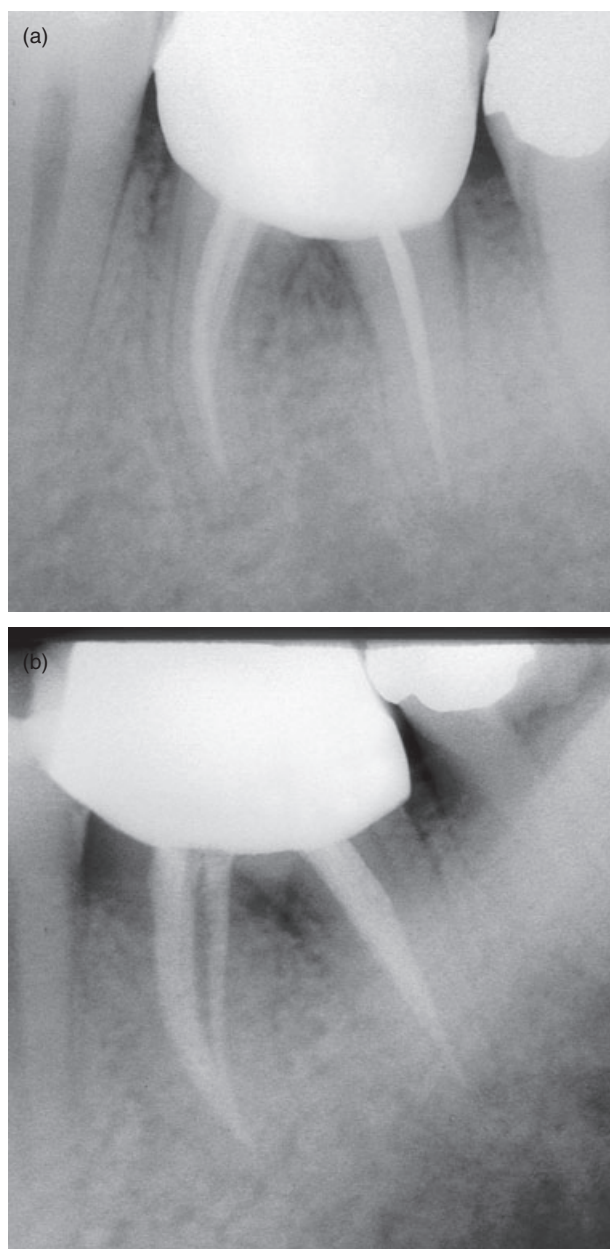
(a) Recall radiograph 1 year after the completion of the treatment. (b) Second recall radiograph taken with distal angle.
